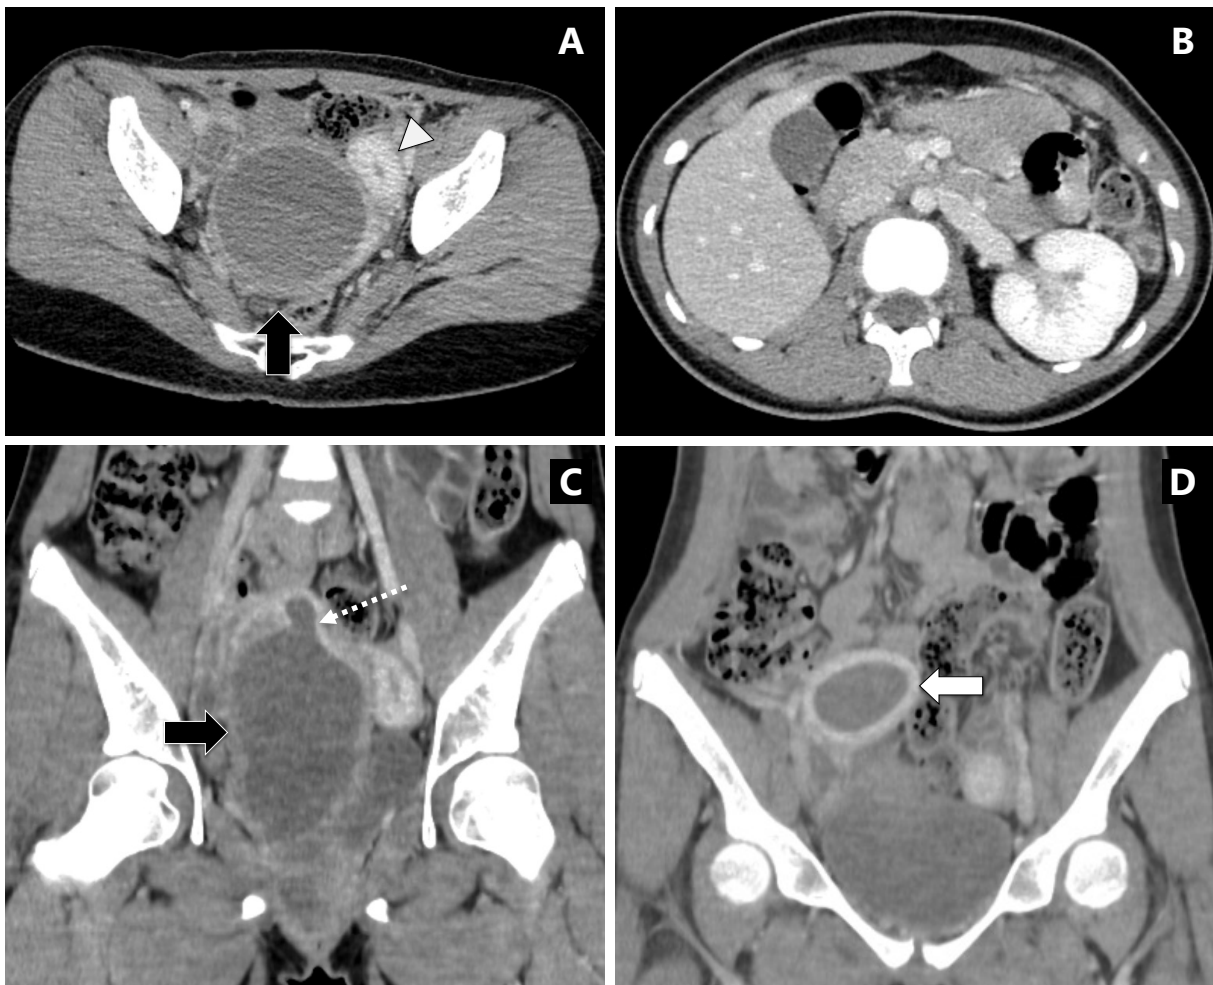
Axial (A, B) and coronal (C, D) contrast-enhanced CT images of the lower abdomen demonstrate hydrocolpos of the right hemivagina (black arrow), communicating with the endocervix (white dotted arrow) and extending into the right uterine horn, which shows hydrometra (white arrow). The left uterine horn is unremarkable (arrowhead). The right kidney is not visualized (B).
